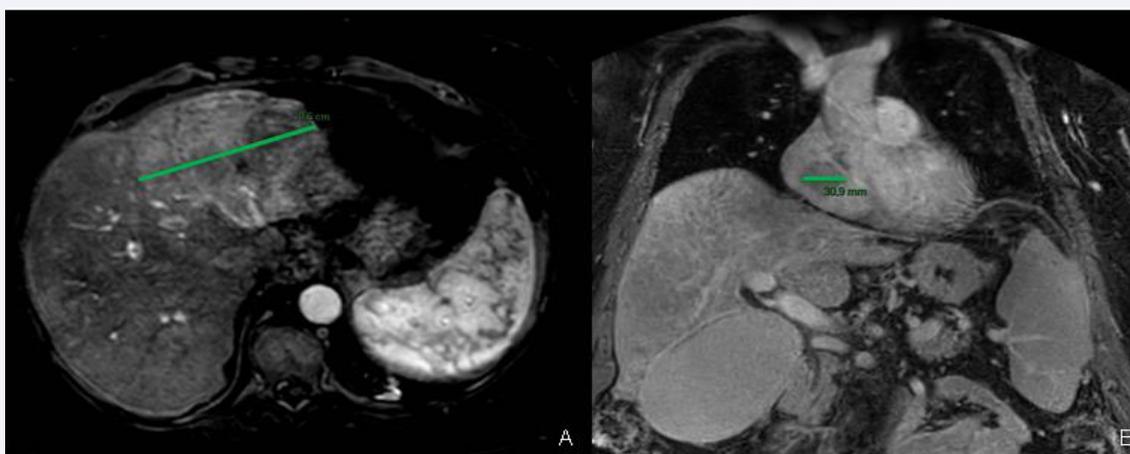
Upper abdomen MRI showing hepatocarcinoma of segment III of 10.5 cm (A); and cardiac metastasis in the right atrium (B)
